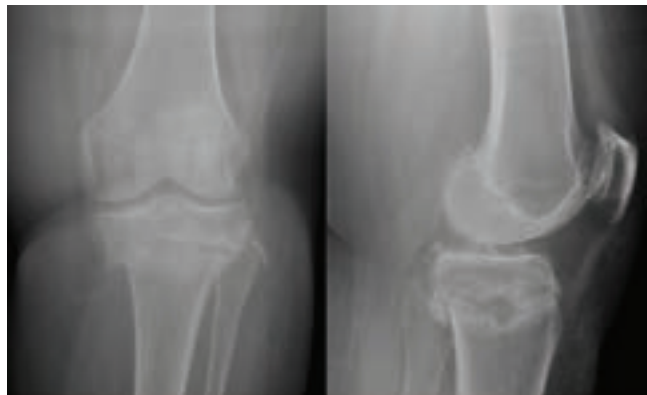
6 weeks post-procedure. AP and lateral radiograph of proximal tibial donor site. Circular cortical defect from autograft harvest is visible on lateral image in addition to global bone resorption throughout the proximal tibial fracture.
